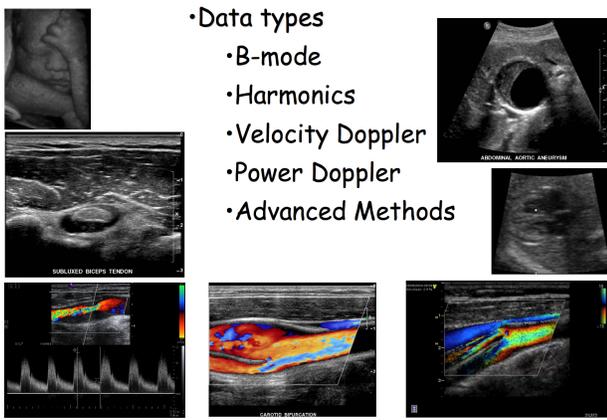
Various types of ultrasound data. (Images courtesy of GE, Philips, Siemens)
